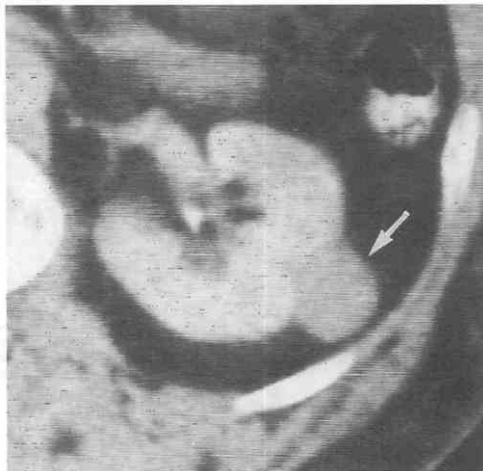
Left renal oncocytoma. A contrast-enhanced CT scan shows a homogeneously enhancing, well-circumscribed, exophytic renal mass (arrow).
